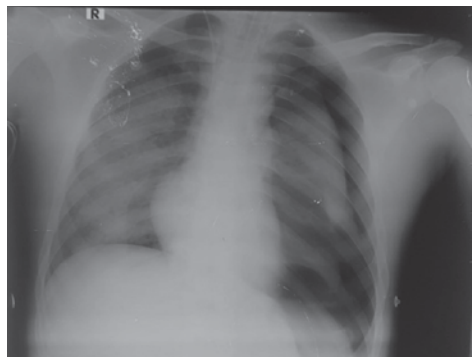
X-ray chest showing left-sided pneumothorax
